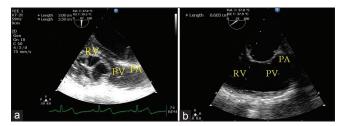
(a and b) Transoesophageal echocardiography-mid oesophageal RV outflow tract view before and after removal of cyst. RV: Right ventricle, PV: Pulmonary valve, PA: Pulmonary artery
